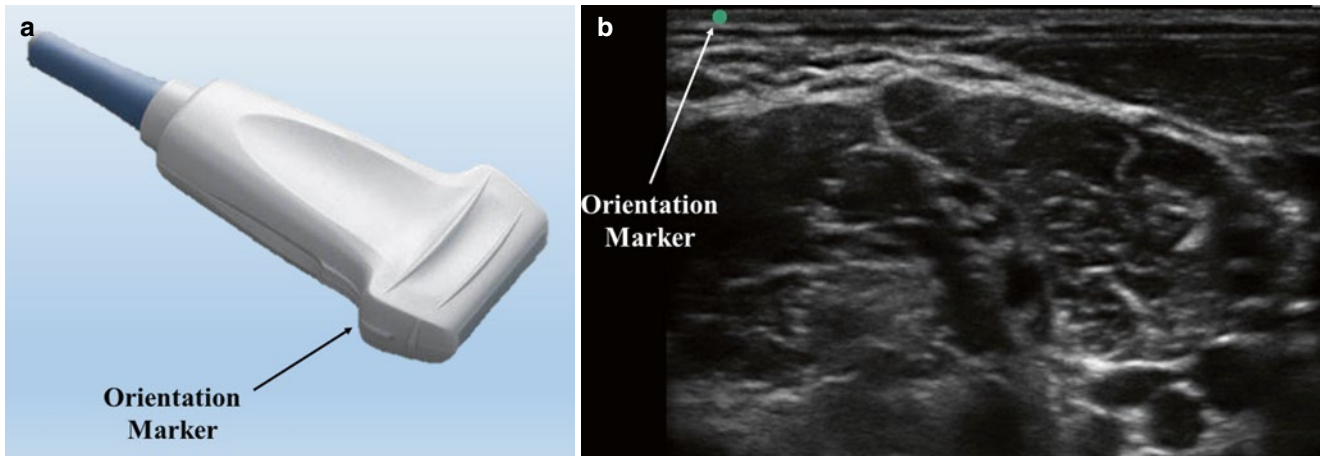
(a) Orientation marker on a linear probe. (b) Orientation marker on the top left corner of the ultrasound screen (Reproduced with permission from www.regionalfortrainees.com)
